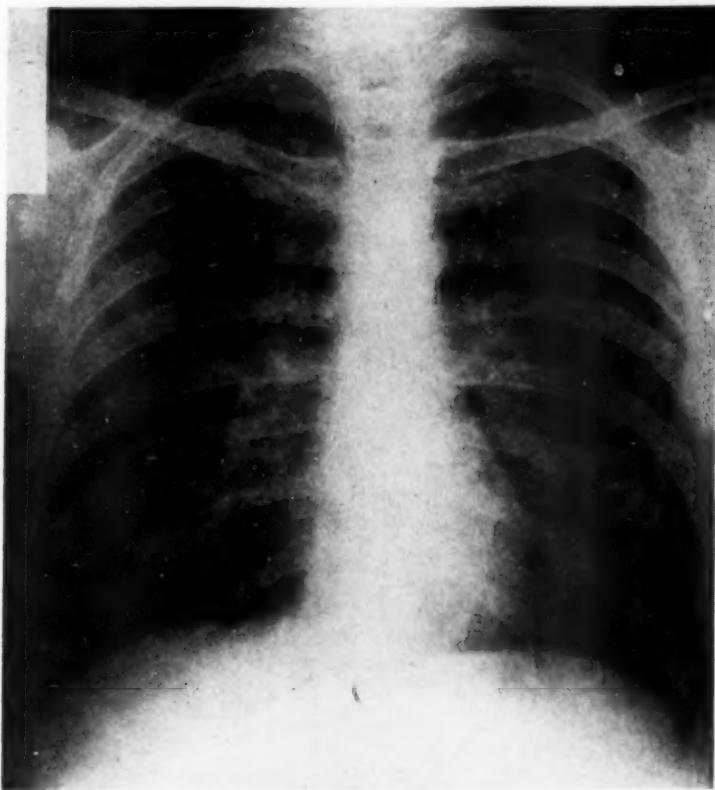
The first abnormal radiograph, taken in October, 1945, showing widespread mottling.
